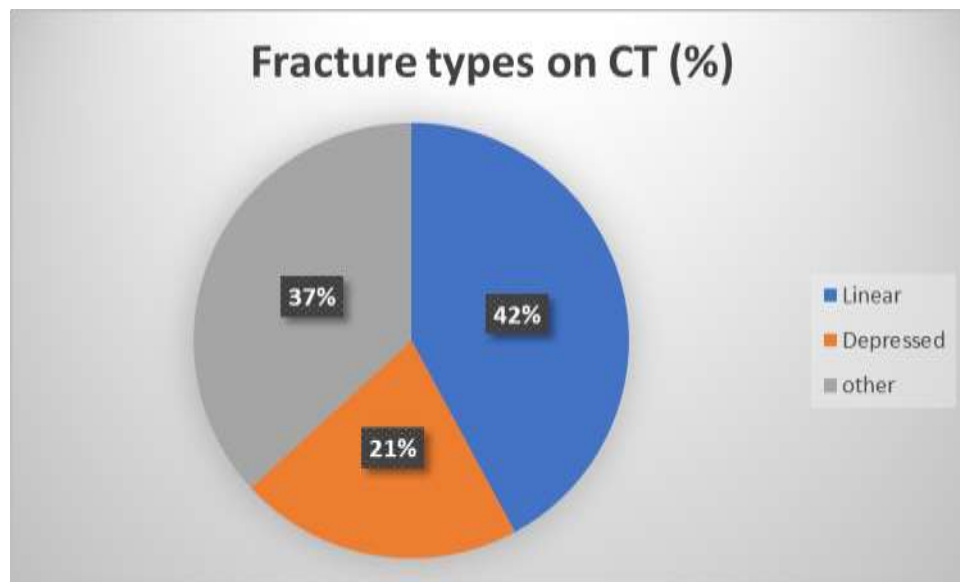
DISTRIBUTION OF CT-CONFIRMED SKULL FRACTURE TYPES (n = 19)
